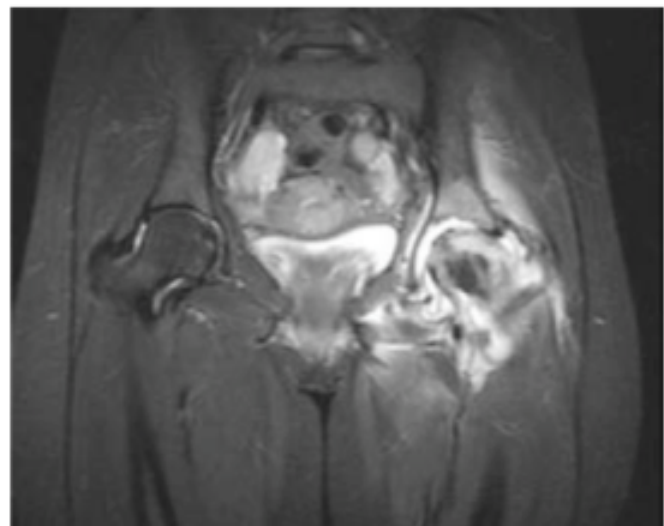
MRI with gadolinium contrast showing intrarticular stiffness of the hip joint, with severe bone turnover on femoral head.
